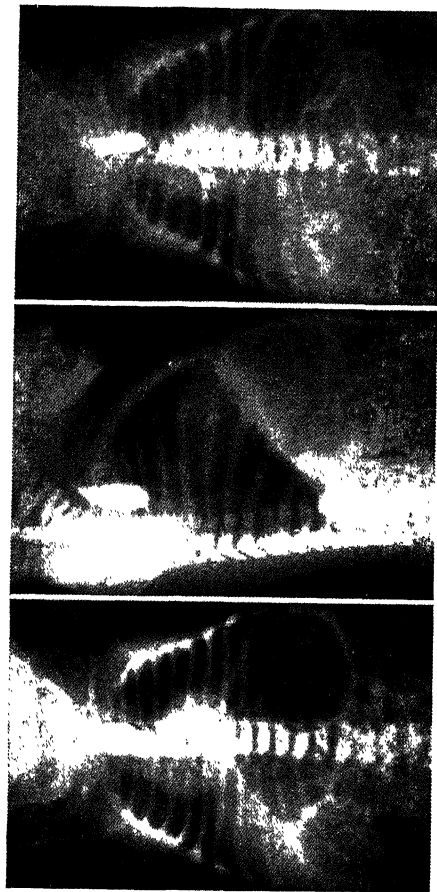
a, b, Frontal and lateral radiographs following the ingestion of lipiodol, showing the blind dilated upper esophageal segment. The stomach and intestines are distended with air, indicating the presence of a tracheo-esophageal fistula. c, Taken one hour later. Retained lipiodol is seen in the upper esophageal segment. Some of the lipiodol has overflowed into the trachea and bronchi, and a small amount has entered the stomach by way of the tracheo-esophageal fistula.
